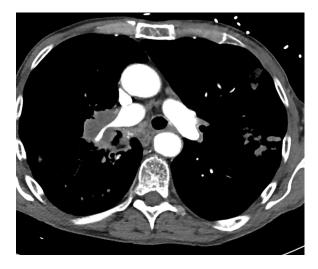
CT axial of the mid chest shows moderate narrowing of distal right main pulmonary artery by hilar mass.
